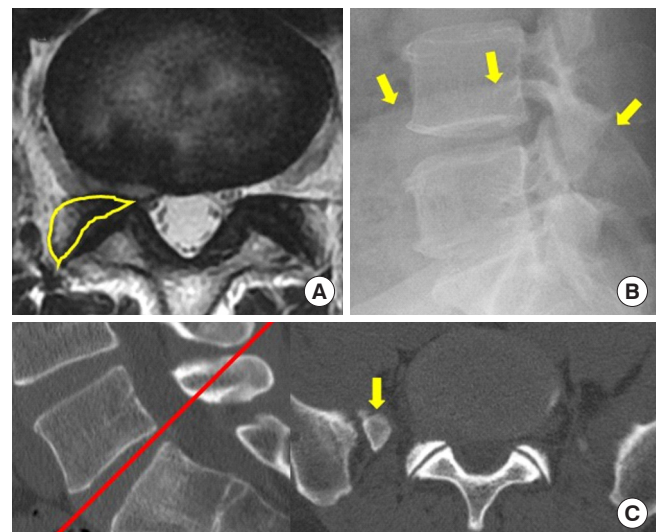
(A) Preoperative measurement of anatomical configurations. The superior articular process area on axial T2-weighted magnetic resonance image was measured as described by An et al.⁷ (yellow polygon). (B) The high position of the iliac crest was defined when the iliac crest (arrows) was located at the L4/5 disc level on lateral plain X roentgen film. (C) Sacral ala hypertrophy was defined as observation of the sacral ala (yellow arrow on the right axial image) on axial computed tomography image at the L5/S1 disc level (the red line on the left sagittal image indicates the level of the right axial image).
